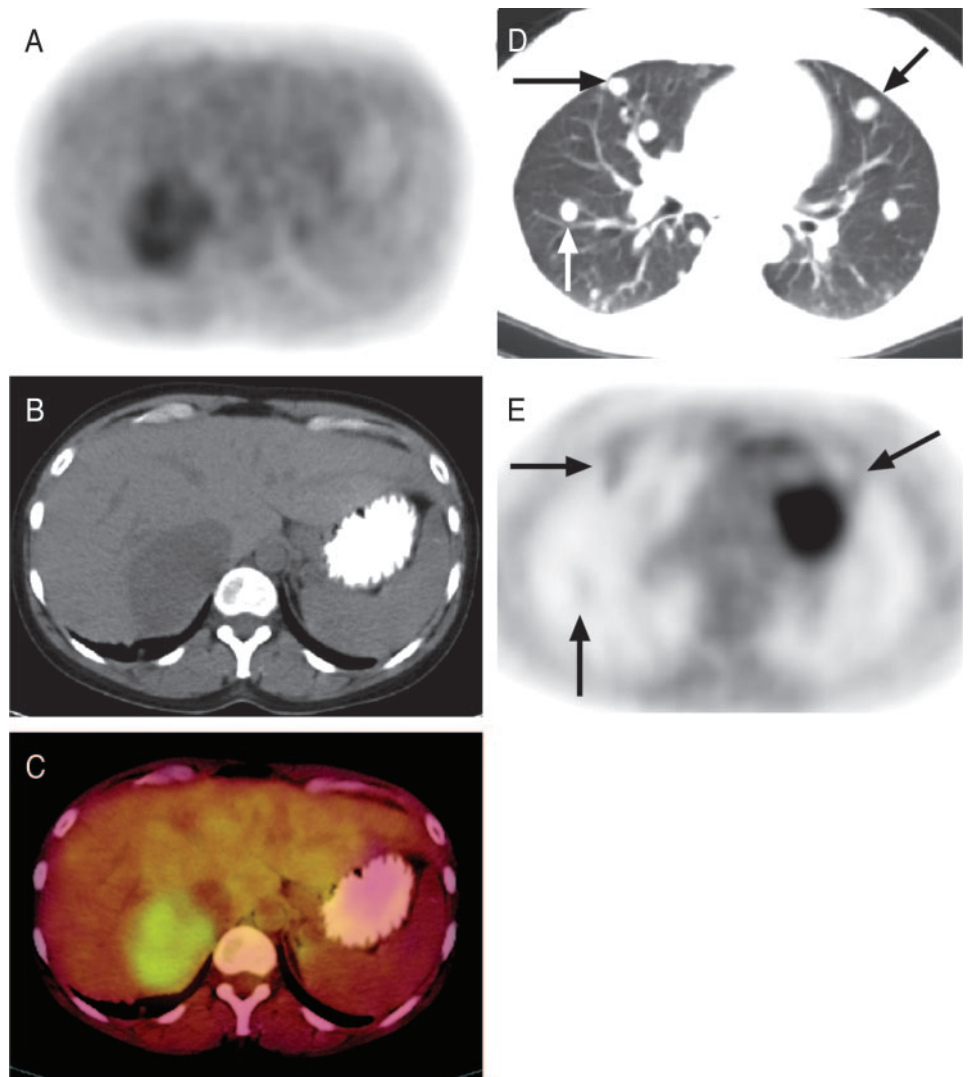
Patient 5, true-positive FDG PET. A–C, Transverse FDG PET (A), concurrent CT (B), and fused PET and CT images (C) demonstrate moderately increased activity in the right adrenal bed (recurrent tumor). D and E, Innumerable pulmonary nodules were apparent on CT (D) (lung windows), but only the larger of these (E) demonstrated activity on FDG PET (the large area of markedly increased uptake is myocardium).
